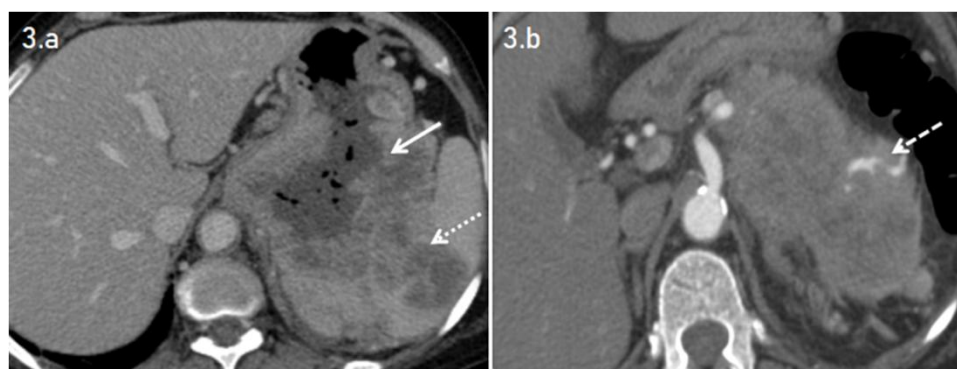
(a & b): 63-year-old case with malignant gastric GIST. Axial views of contrast-enhanced CT study of abdomen in venous (a) and arterial (b) phases show an exophytic, heterogeneously enhancing mass lesion (solid arrow) with central necrosis seen arising from the fundus of the stomach. The lesion is seen to infiltrate the splenic hilum (dotted arrow) with one third of the splenic parenchyma being replaced by the mass lesion. A prominent arterial feeder (dashed arrow in b) is seen arising from the splenic artery.
